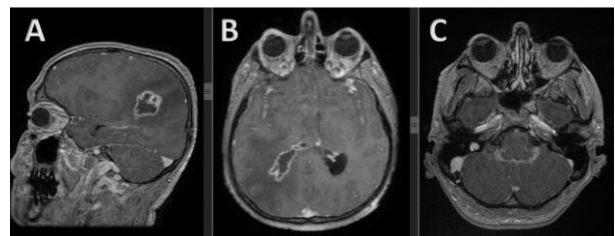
Brain MRI shows contrast ring enhancement on sagittal (A) and axial (B) plane. At the basal cisterns the contrast enhancement is suggestive for pachymeningitis (shown with blue arrows).
